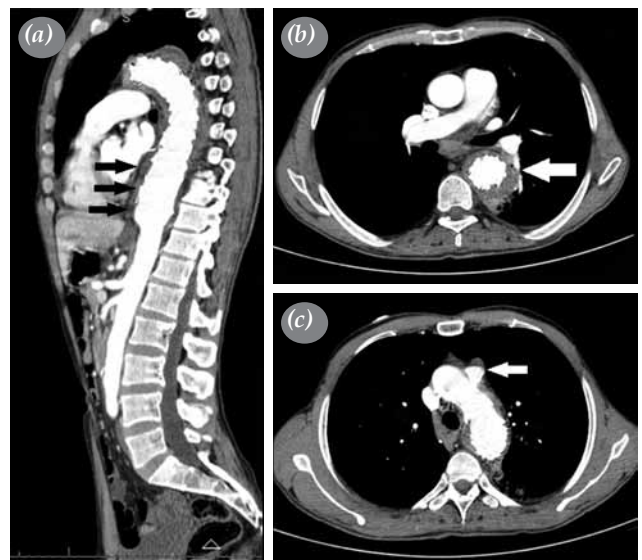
Repeated computed tomographic angiography showing (a and b) the progression of the pseudoaneurysm sac formation inferiorly surrounding the second stent graft in the descending thoracic aorta and (c) the progression in size of the saccular pseudoaneurysm proximal to the first stent graft.
